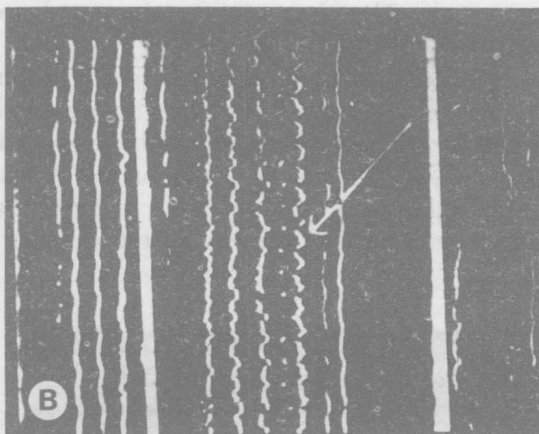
Fetal heartbeat (arrow) obtained from the inner cell mass of the gestational sac above by focusing ultrasonogram beam through gestational sac. (Courtesy of Prof. Ian Donald)
